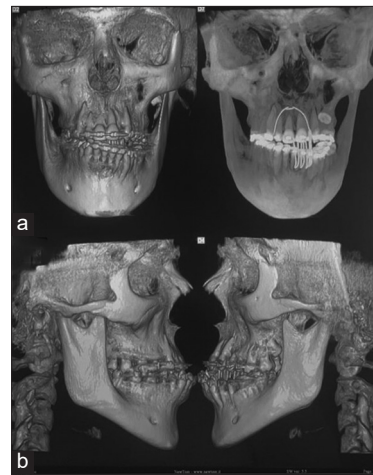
(a) Presurgical coronal view of cone beam computed tomography (CBCT) image. (b) Presurgical lateral view of CBCT image.
